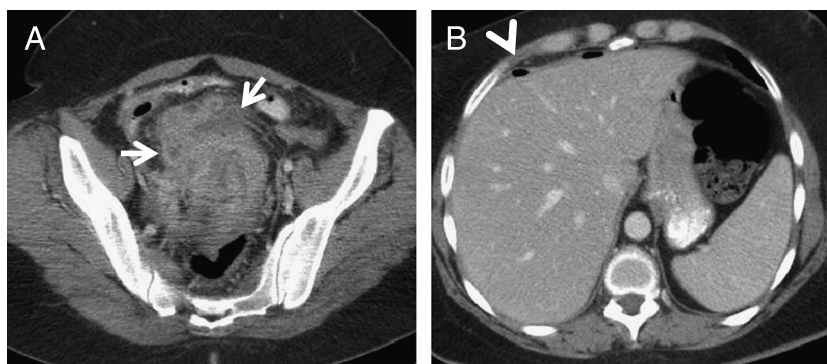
Colonic perforation in a 76-year-old man with the diagnosis of sigmoid colon cancer. Axial contrast-enhanced CT images of the abdomen at different levels show heterogeneously enhancing mass arising from the sigmoid colon with extensive pericolic fat stranding (arrows) and associated free intraperitoneal air (arrowhead) suggestive of perforation.
